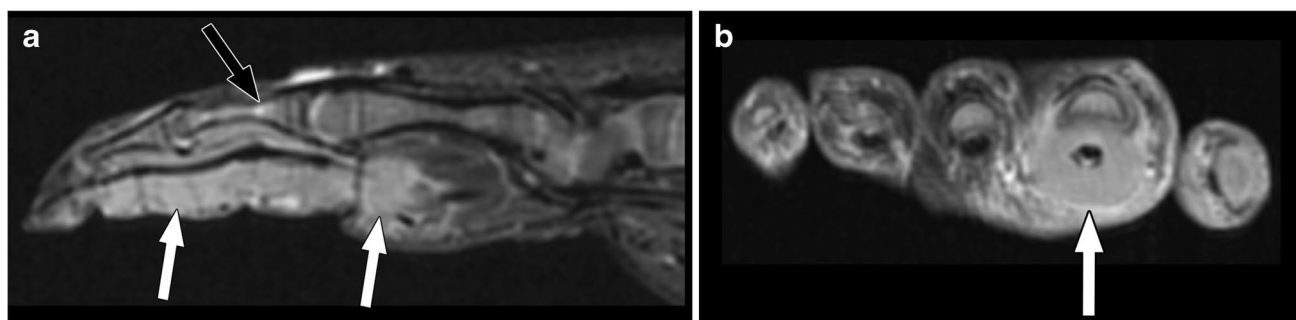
2-month-old boy with tenosynovitis and osteomyelitis due to disseminated coccidioidomycosis. a Sagittal T2-weighted MR image of the index finger shows extensive abnormal T2-weighted hyperintense signal in the volar soft tissue of the finger (white arrows) surrounding the flexor tendons, consistent with tenosynovitis, as well
